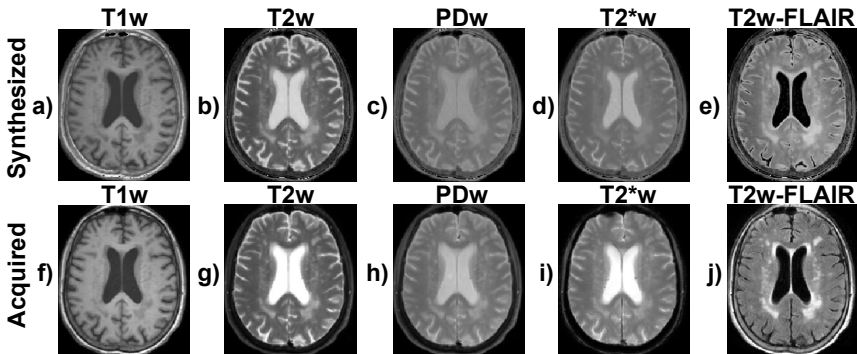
A representative axial slice of the non skull-stripped weighted images synthesized from one set of the T1, T2, and PD maps computed by the CNN and their corresponding non skull-stripped acquired images. a-e) The synthesized T1w, T2w, PDw, T2*w, and T2w-FLAIR images. f-j) Their corresponding weighted acquired images.
